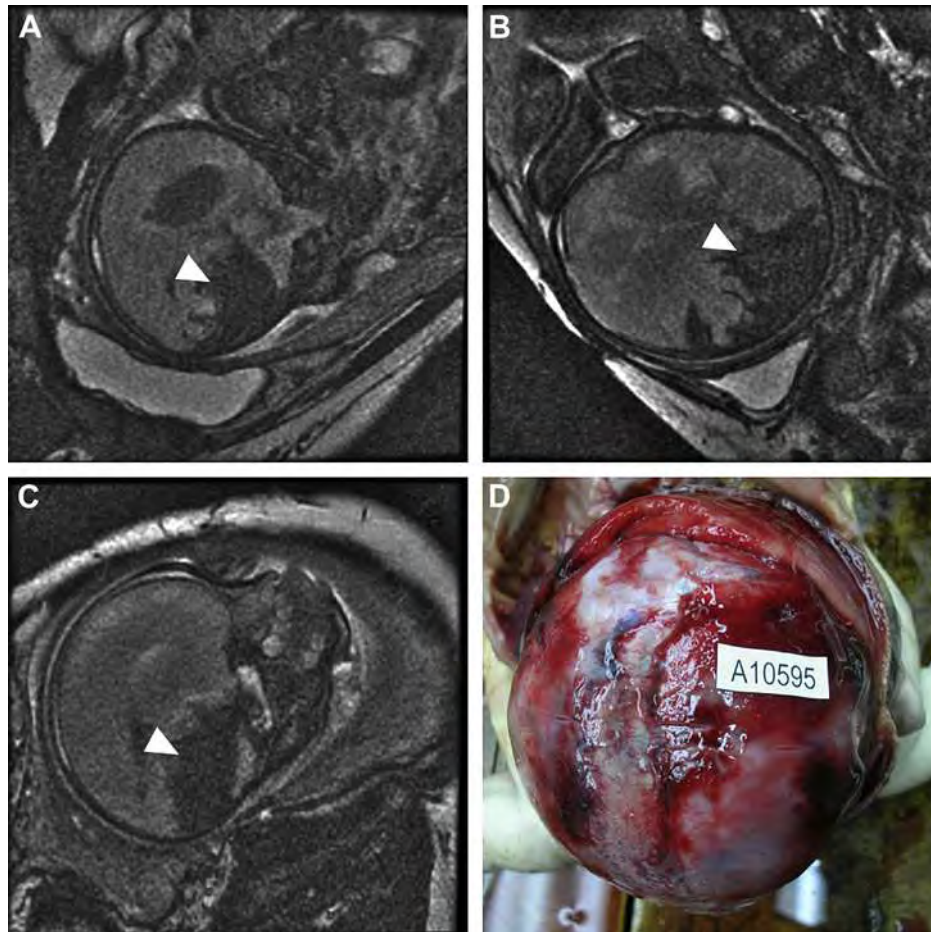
Different views of magnetic resonance images and fast imaging employing steady-state acquisition images demonstrate the intracranial cerebral hemorrhage. (A) Coronal view, (B) axial view, (C) sagittal view, and (D) the fetal brain autopsy gross view.
